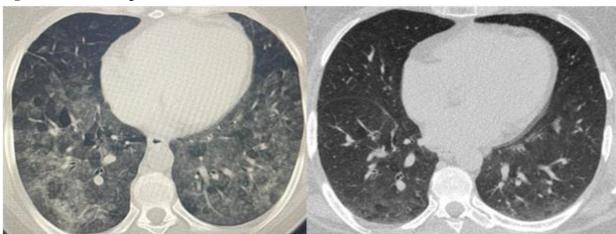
HRCT findings of case nine before and after steroid treatment
